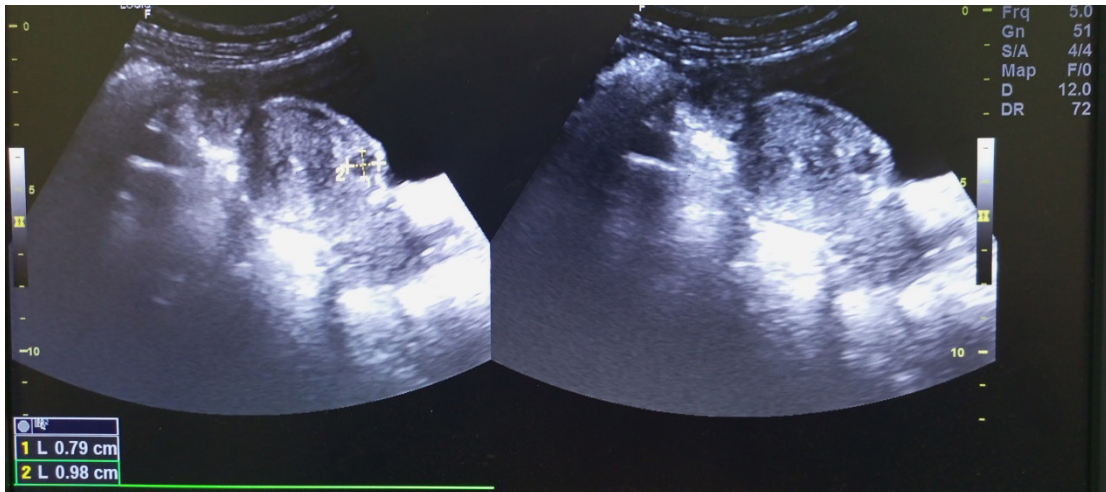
Static grey scale sonograms of a subserosal heterogeneous but predominately hypoechoic mass in the anterior aspect of the uterus measuring approximately 9.8mmX7.9mm.
